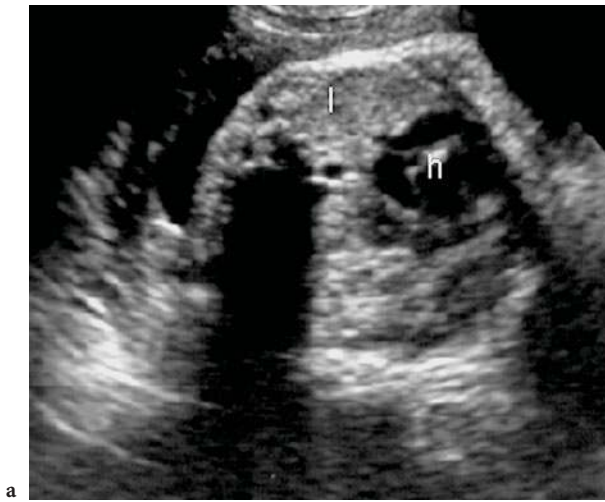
a Left side CDH transverse four-chamber view showing the fluid filled stomach at the level of the fetal heart that is displaced towards the right. b Left-sided congenital diaphragmatic hernia. Transverse sonogram displaying the cardiac shift, the posterior stomach, and the more anterior left lobe of the liver (*h* heart, *li* liver, *st* stomach)
